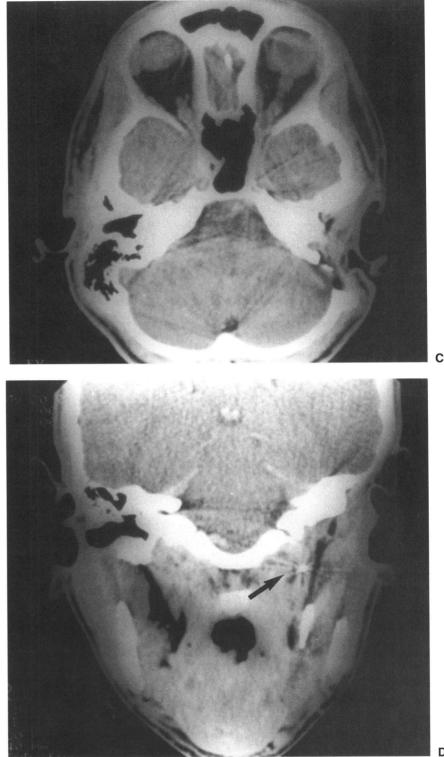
(Continued). C. Postoperative (3 years) axial CT showing complete tumor removal and the exenterated temporal bone. D. Postoperative (3 years) coronal CT showing complete removal of tumor and position of the proximal balloon occluding the left common carotid artery (↔).
